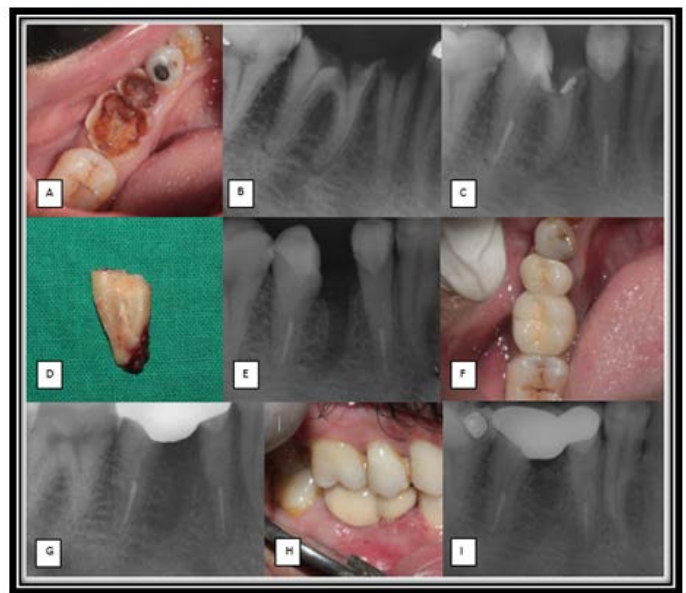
(A) Preoperative Photograph, (B) Preoperative radiograph, (C) Radiograph following RCT and Fiber post placement, (D) Hemisected mesial root, (E) Immediate post Hemisection radiograph, (F) Occlusal view of fixed partial denture, (G) and (H) 2 month follow up radiograph and photograph, (I) 1 year follow up radiograph.
